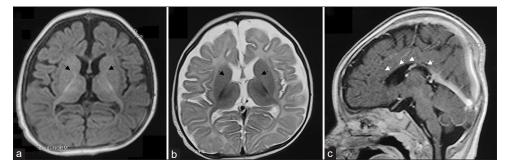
MRI brain at 6 m of age: Axial T1w (a) and T2w (b) images show lack of myelination in the anterior limb of internal capsule (black arrows). There is mild diffuse atrophy of the brain with white matter loss and prominent sulcal spaces. (c) Sagittal post-contrast T1w images show lack of myelination in corpus collosum with marked atrophy
